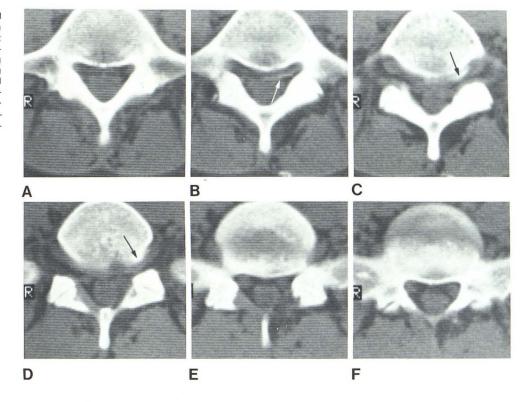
Postoperative recess and foraminal compromise. Low back pain and left radiculopathy 8 years after left L5–S1 diskectomy. CT scans (bone windows) show linear bony spur traversing left recess (white arrows) and becoming more dense exostosis from vertebral body (black arrows). This is compromising the left neural foramen. Postoperative bony overgrowth causing lateral stenosis is more likely to arise from vertebral body than from superior facet.
